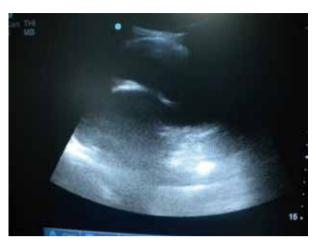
Ultrasonographic appearance of the pleural effusion.
